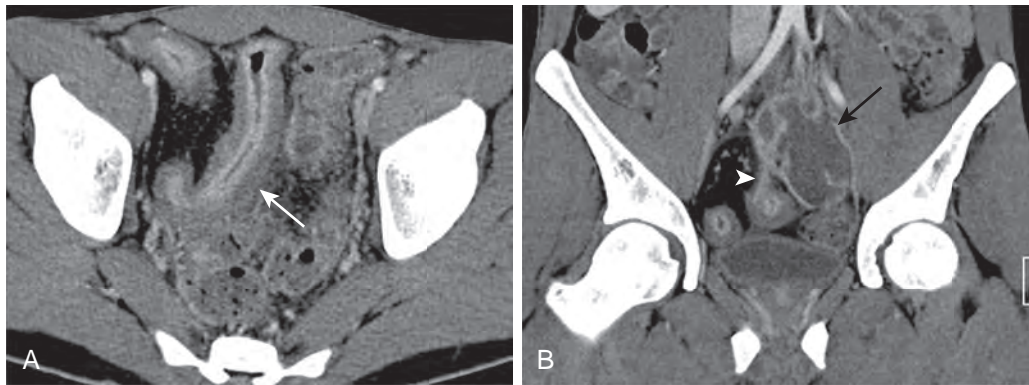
Mixed fibrostenotic and active inflammatory small bowel Crohn's disease of the distal ileum with penetrating disease: Bilaminar hyperenhancement. CT enterography in axial (A) and coronal (B) reconstructions show bilaminar hyperenhancement, severe wall thickening (>1 cm) (white arrow), and a fistulous tract extending cephalad (arrowhead) toward an abscess (black arrow).
